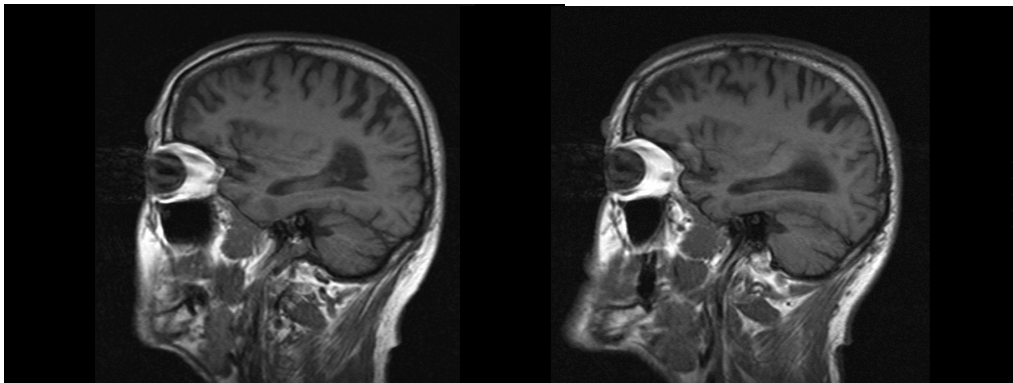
MRI scan (sagittal T1) of PB's brain.
